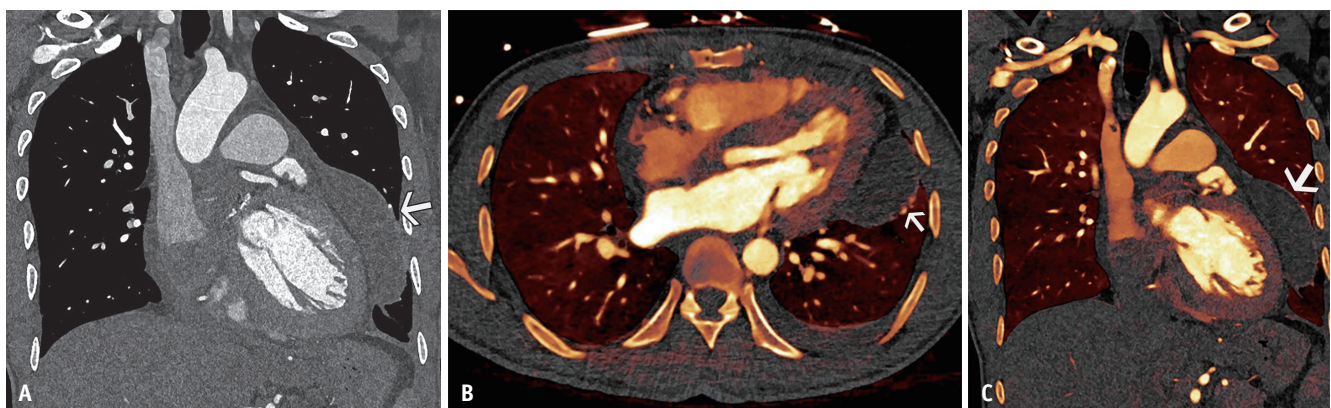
Multienergy characterization of incidental lesion. A: Coronal oblique CT angiography in a 42-year-old male post-Bentall procedure, subaortic resection, Konno root enlargement, and tricuspid annuloplasty shows a complex hyperattenuating mediastinal hematoma (arrow). B, C: Axial (B) and coronal (C) iodine maps in the same patient show absence of iodine in the lesion (arrows), confirming the lesion as a postoperative seroma.
